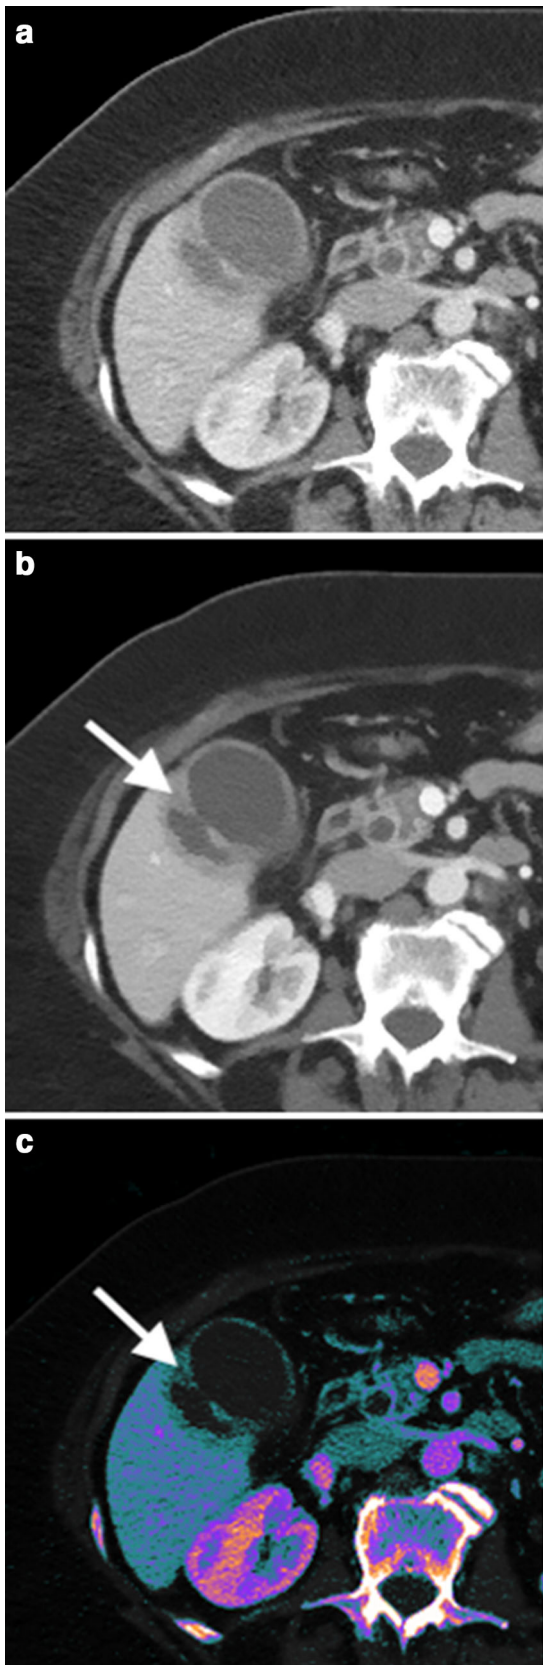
Eighty-year-old female with acute cholecystitis, presenting with right upper quadrant pain for 5 days. Conventional CT image from a contrast-enhanced SDCT as shown in (a) demonstrating mild gallbladder wall enhancement concerning for acute cholecystitis. A subtle defect is noted in the lateral wall of the gallbladder with an adjacent elliptical fluid collection concerning for focal perforation of the gallbladder wall and associated abscess. 50 keV VME reconstruction (b) and color-coded iodine overlay (c) better depict the gallbladder wall defect as a focal area of nonenhancement, and confirm the rim enhancement and lack of central enhancement of the adjacent abscess
